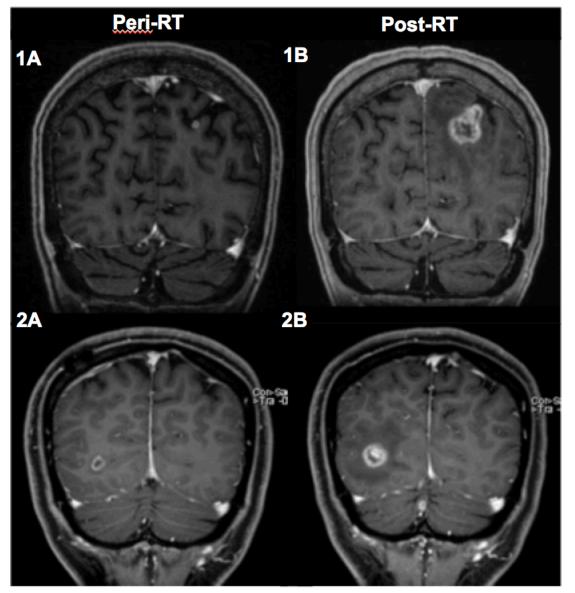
Representative axial post-contrast magnetic resonance images (MRI) of pathologically confirmed radiation necrosis in an immunotherapy-naïve (1A/B) and an immunotherapy-treated (2A/B) patient, respectively [MRI sequence: 1A/B, BRAVO; 2A, MP RAGE; 2B, STEALTH 3D FSPGR]
